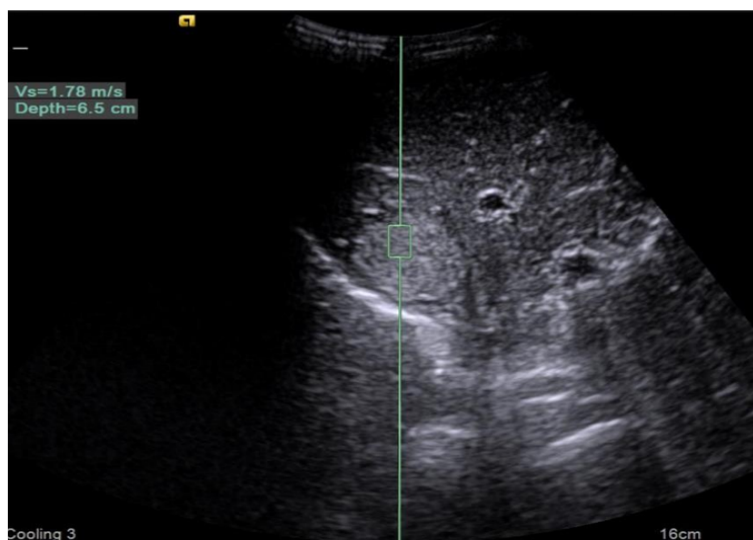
Ultrasound elastography in a focal nodular hyperplasia
